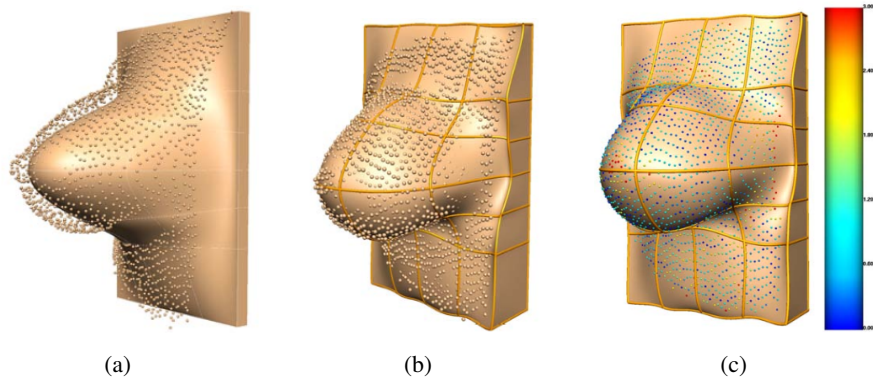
Fitting results from the work by Rajagopal *et al.* [154]. (a) and (b) showing the mesh before and after fitting the MRI data to the 3D surface model. (c) final fitting with an error of 1.18 *mm* reported for the current model. The colored points represent the skin 3D surface model showing the individual error magnitude, in millimeters.
